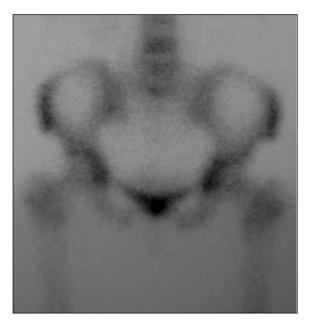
Bone scintigraphy showing hyper-captation of radionuclide characterizing symphysitis pubis
